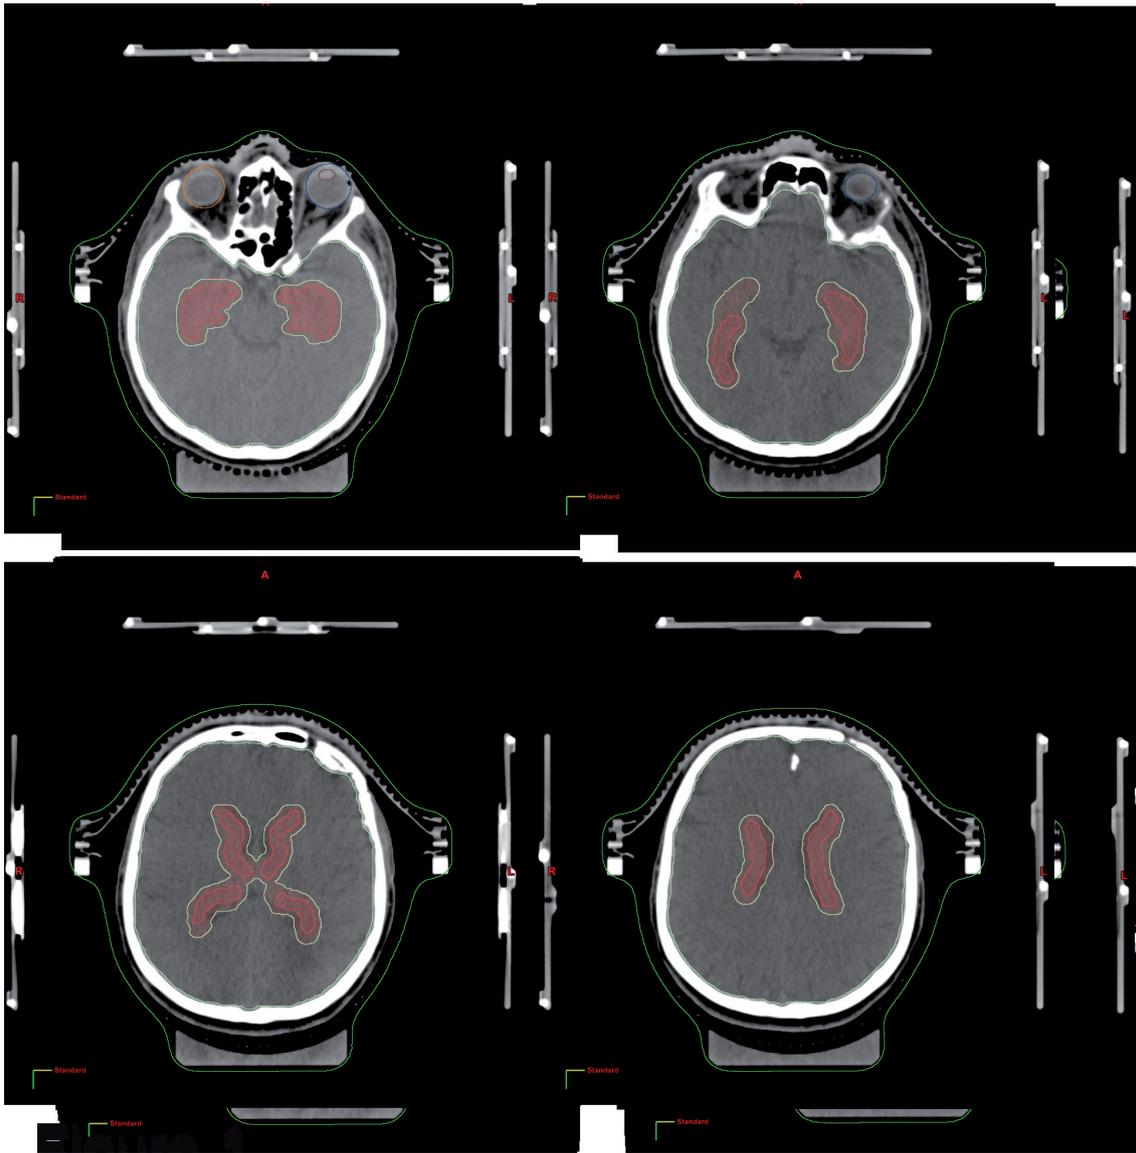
The shape of the Neural Stem Cells Region (NSC) for a reduced irradiation dose after transfer of MRI data to CT (test patient). The PTV was defined as the whole brain volume excluding the NSC compartments. This volume contains regions thought to contain neural stem cells with a 4-mm margin. The volume for the reduced dose included a narrow 2-mm external wall strip of the lateral ventricle with a 4-mm margin in the medial and lateral directions (SVZ). This region at the end of temporal horn is joined to the hippocampus (SGZ).
